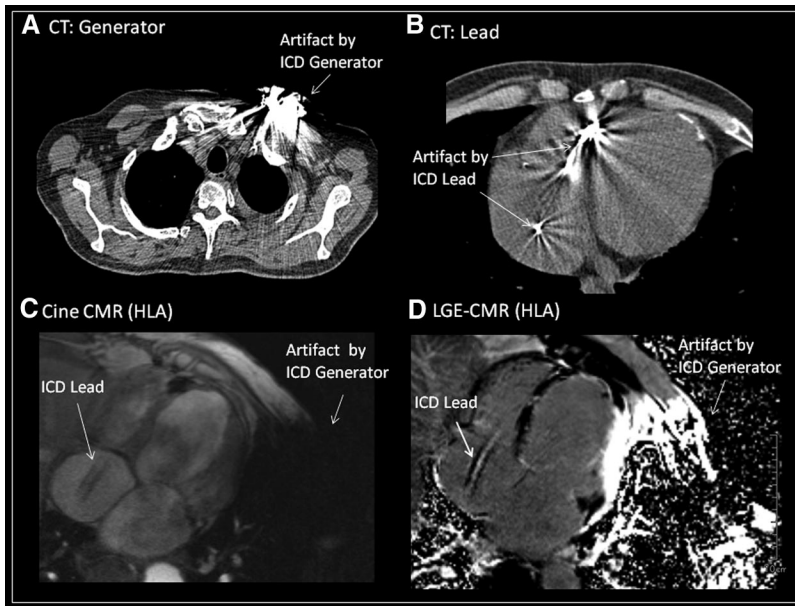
Artifact effects on late gadolinium-enhanced (LGE) cardiac magnetic resonance imaging caused by pacemaker and implantable cardioverter-defibrillator pacemaker/implantable cardioverter-defibrillator (ICD) leads. Comparison of artifacts caused by the ICD generator and lead in both computed tomography (CT) (A and B) and MRI (C and D) in a patient with single-chamber ICD. Artifacts caused by the lead were smaller on MRI compared with CT. In contrast, artifacts caused by the generator were larger with MRI.
